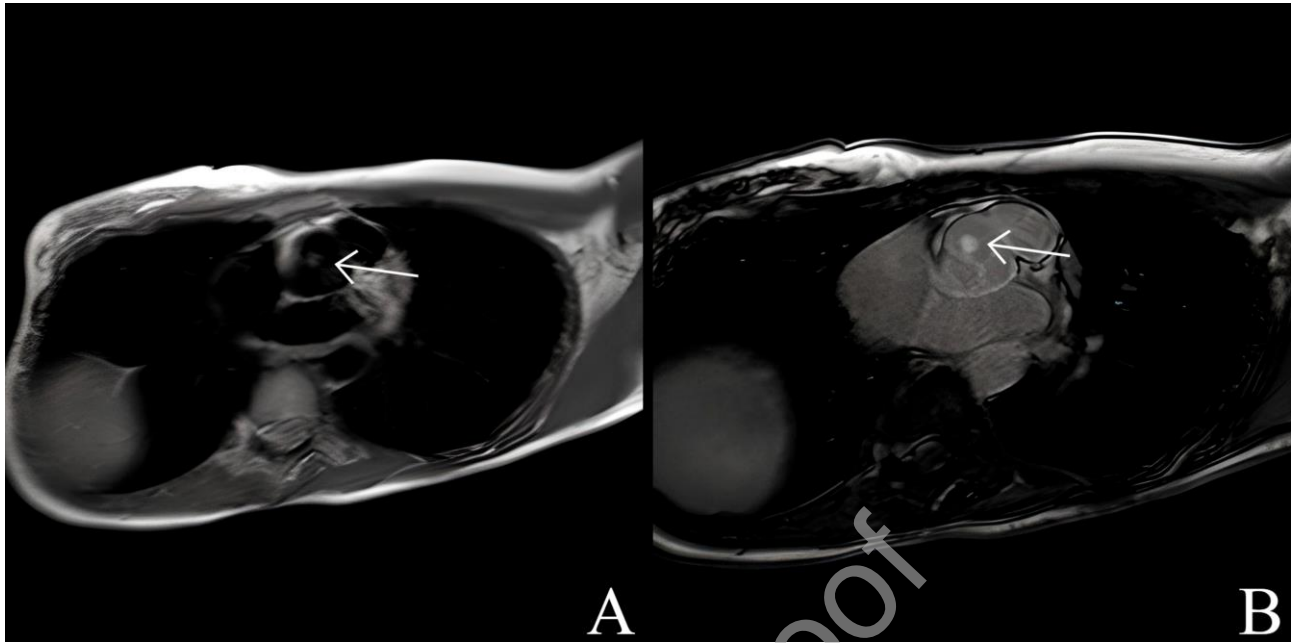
(A) On Cardiac magnetic resonance (CMR), T1-weighted imaging showed an isointense mass on the right cusp of the aortic valve (arrow). (B) The study of late gadolinium enhancement (LGE) in phase-sensitive inversion recovery (PSIR) demonstrated higher signal of the mass (arrow) compared with the myocardium.
